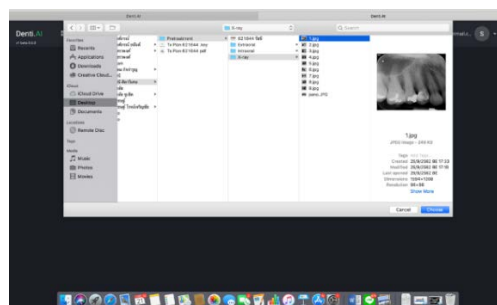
Radiographic image selection
